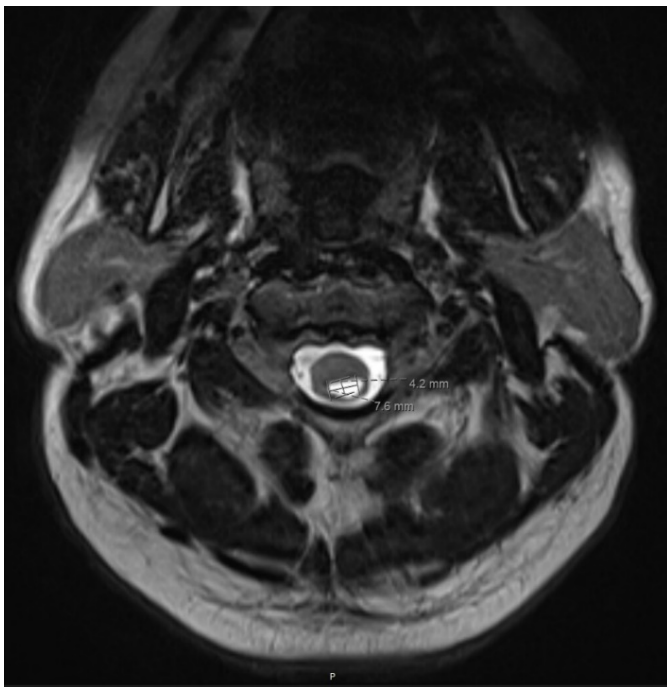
MR C spine T2-weighted axial view of the posterior cervical syrinx measured at approximately 4 x 8 mm.
